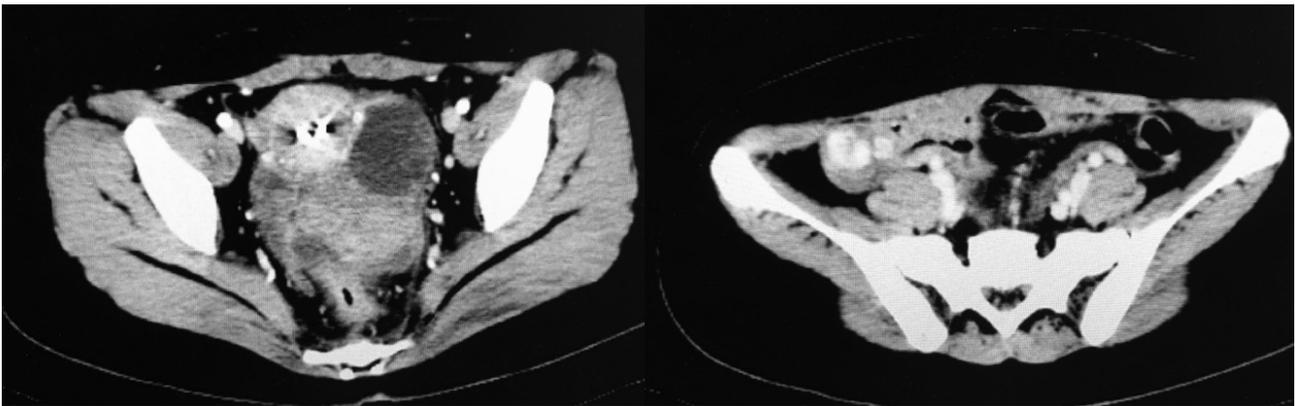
CT views of the second surgery.
